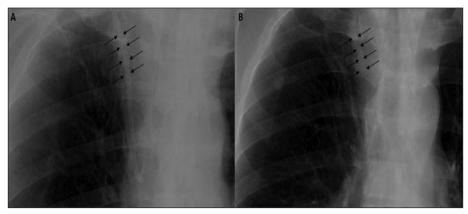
Pre-removal (A) and post-removal (B) chest X-ray images depicting peri-catheter fibrin cast prior to and after catheter removal (arrows).
